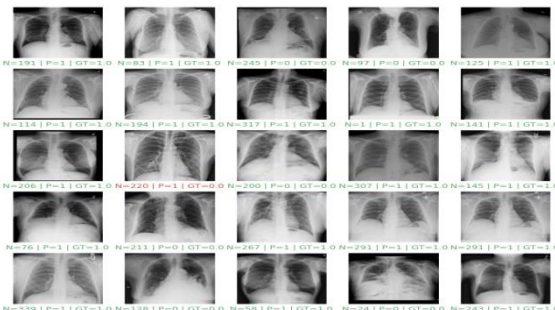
Randomly detecting COVID-19 on X-ray images
